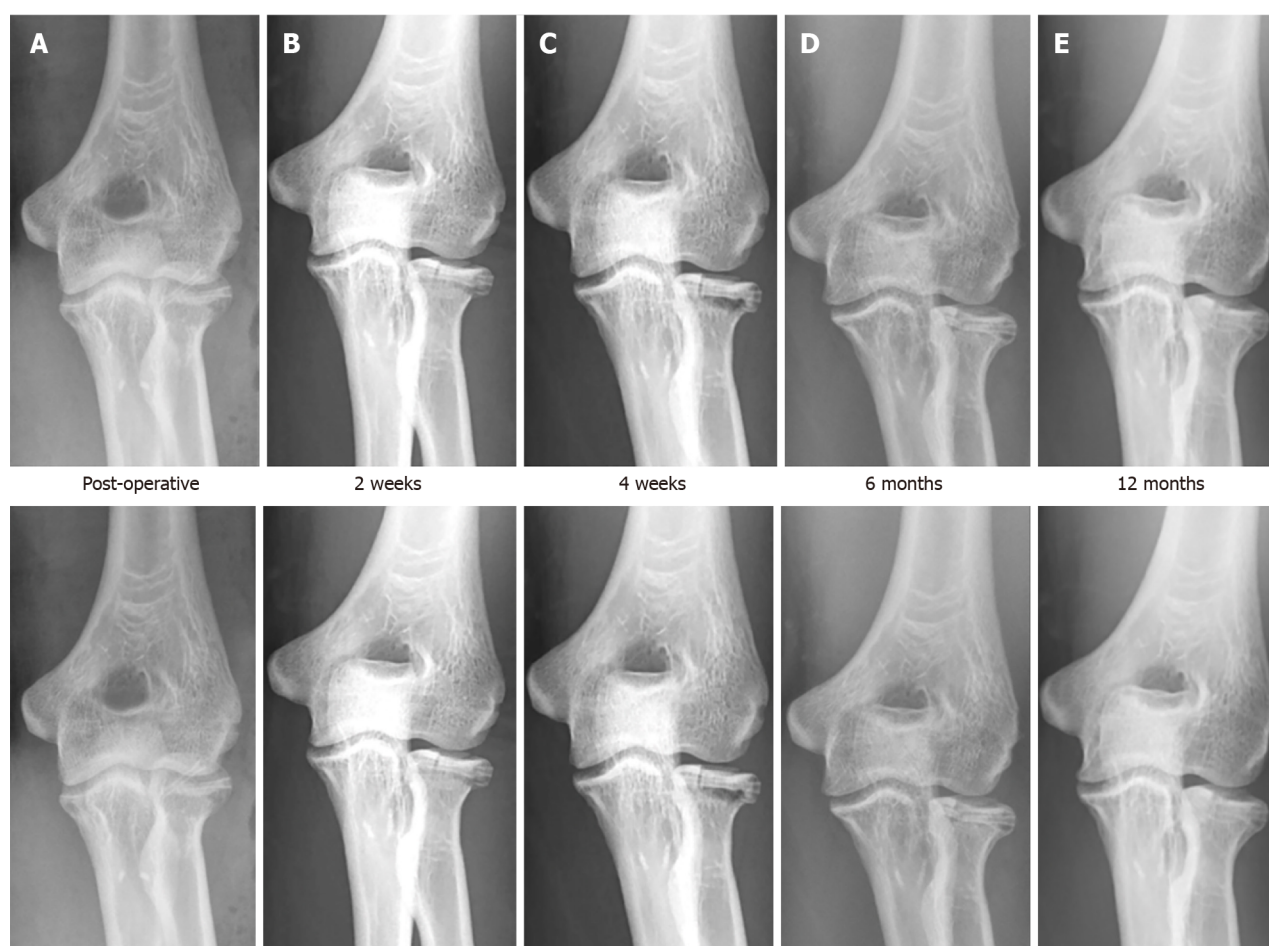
Post operative radiographs. A-E: Radiographs immediately post op (A), at 2 weeks (B), 4 wk (C), 6 months (D) and 12 months (E).
